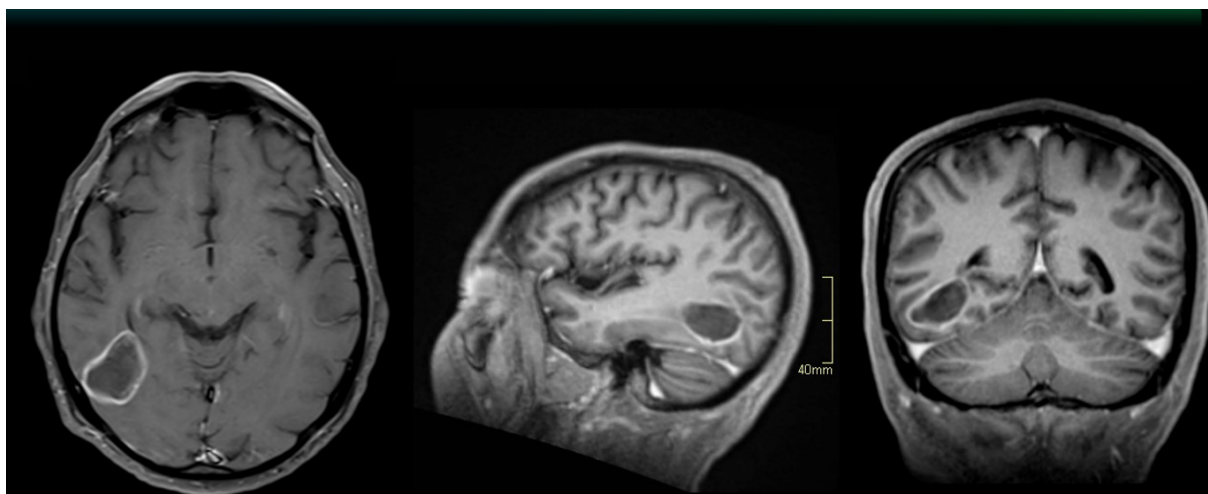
T1-weighted magnetic resonance image demonstrating a ring-enhancing lesion in the right temporal-parietal-occipital region, with perilesional vasogenic edema. The lesion was characterized by a core of restricted diffusion (not shown) with no signs of infiltration. A) Axial plane; B) Sagittal plane; C) Coronal plane
